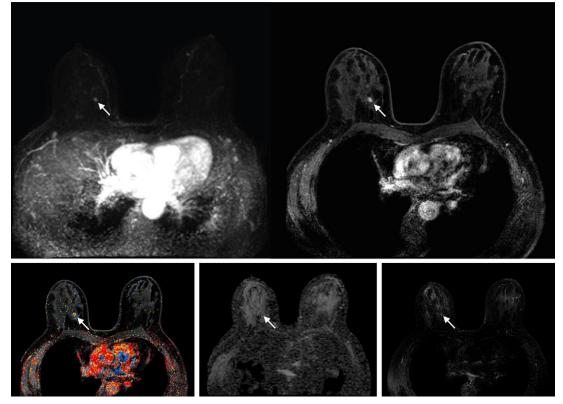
Abbreviated axial MRI images show a 6-mm irregular mass with an irregular margin (arrows) in the right upper inner quadrant with early rapid enhancement. The lesion was assessed as Breast Imaging Reporting and Data System (or BI-RADS) category 4 (suspicious for cancer). The participant was recalled and underwent US-guided core-needle biopsy that showed invasive carcinoma of no special type. On the full-protocol sequences (not shown), the lesion was T2-weighted hypointense and showed diffusion restriction and washout kinetics in the delayed phase, characteristics that, although are all confirmative of the malignant nature of the lesion, offered no additional value for making the recall decision.
